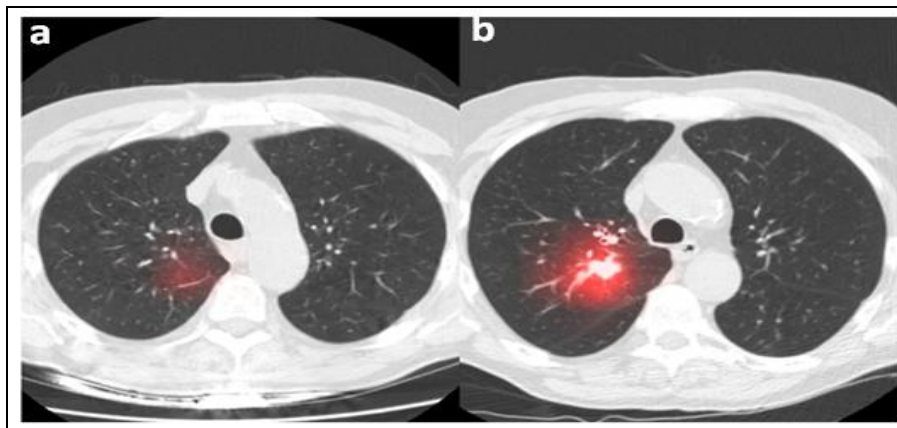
CT SCAN OF PATIENT SUFFERING FROM LUNG CANCER (A) PREVIOUS SCAN (B) TWO YEAR LATER SCAN (<https://www.nbcnews.com/health/health-news/promising>)
